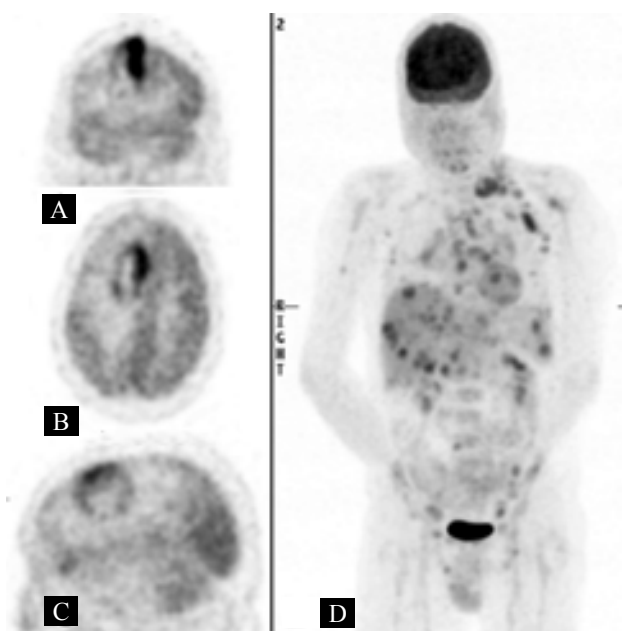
(A) Coronal, (B) Transaxial and (C) Parasagittal PET images of the brain showing a focal 'hot' lesions in the right frontal lobe medially with a central photopenic deficit. (D) ^{18}F -FDG PET maximal intensity projection image demonstrating extensive metastatic disease.
